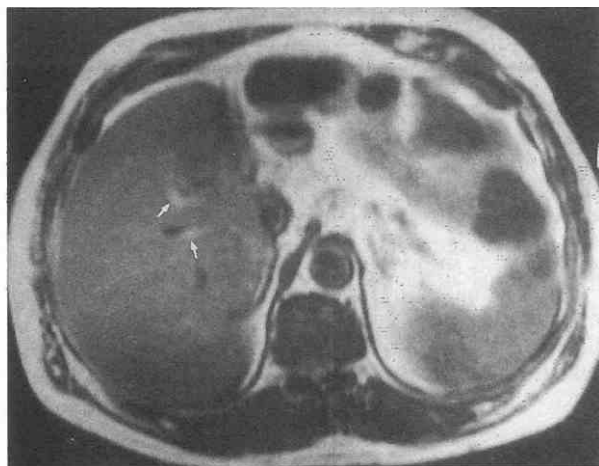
T1-weighted image of subtle intrahepatic biliary dilatation (*arrows*). The dilated ducts are hyperintense because of the concentration of the bile. Adjacent vessels have relatively low signal. TR = 500; TE = 20.
